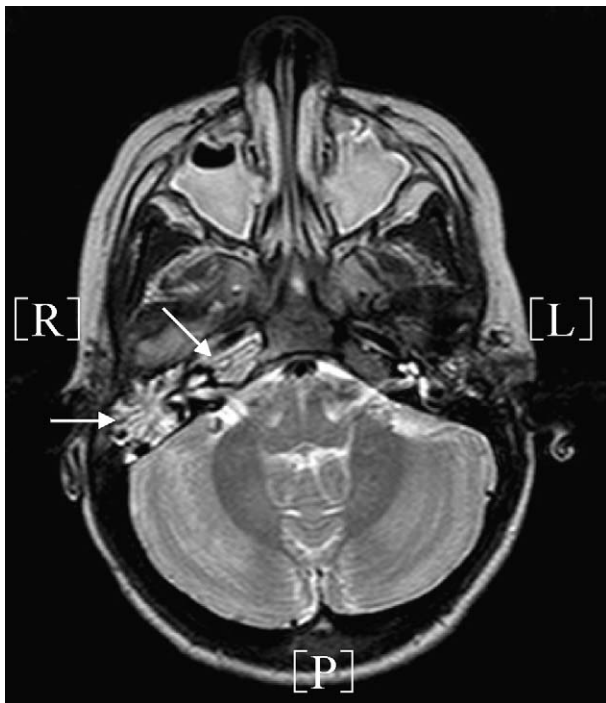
MRI. Axial image T2 weighted. Hypersignal of the right mastoid and petrous apex indicated by the arrows.
